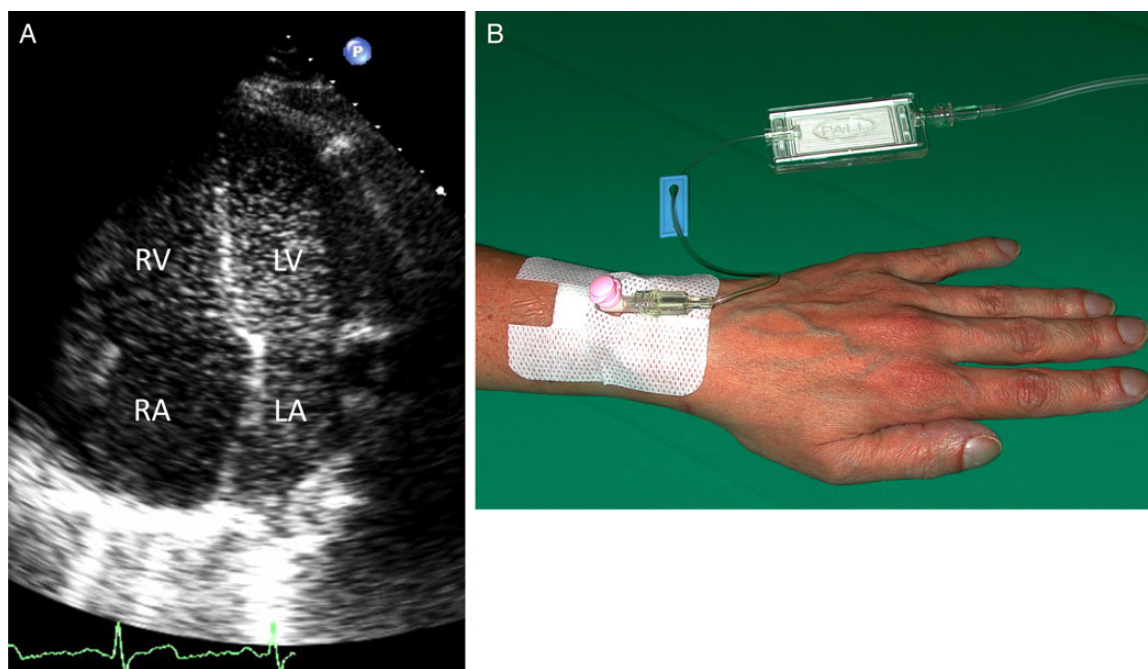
Residual intra-cardiac shunt with risk of paradoxical embolism. (A) Echocardiographic four-chamber view after injection of agitated saline contrast in a patient with sinus venosus defect, demonstrating large, spontaneous right-to-left shunting. (B) Intravenous line with air filter (bubble trap) to prevent accidental systemic air embolism.
